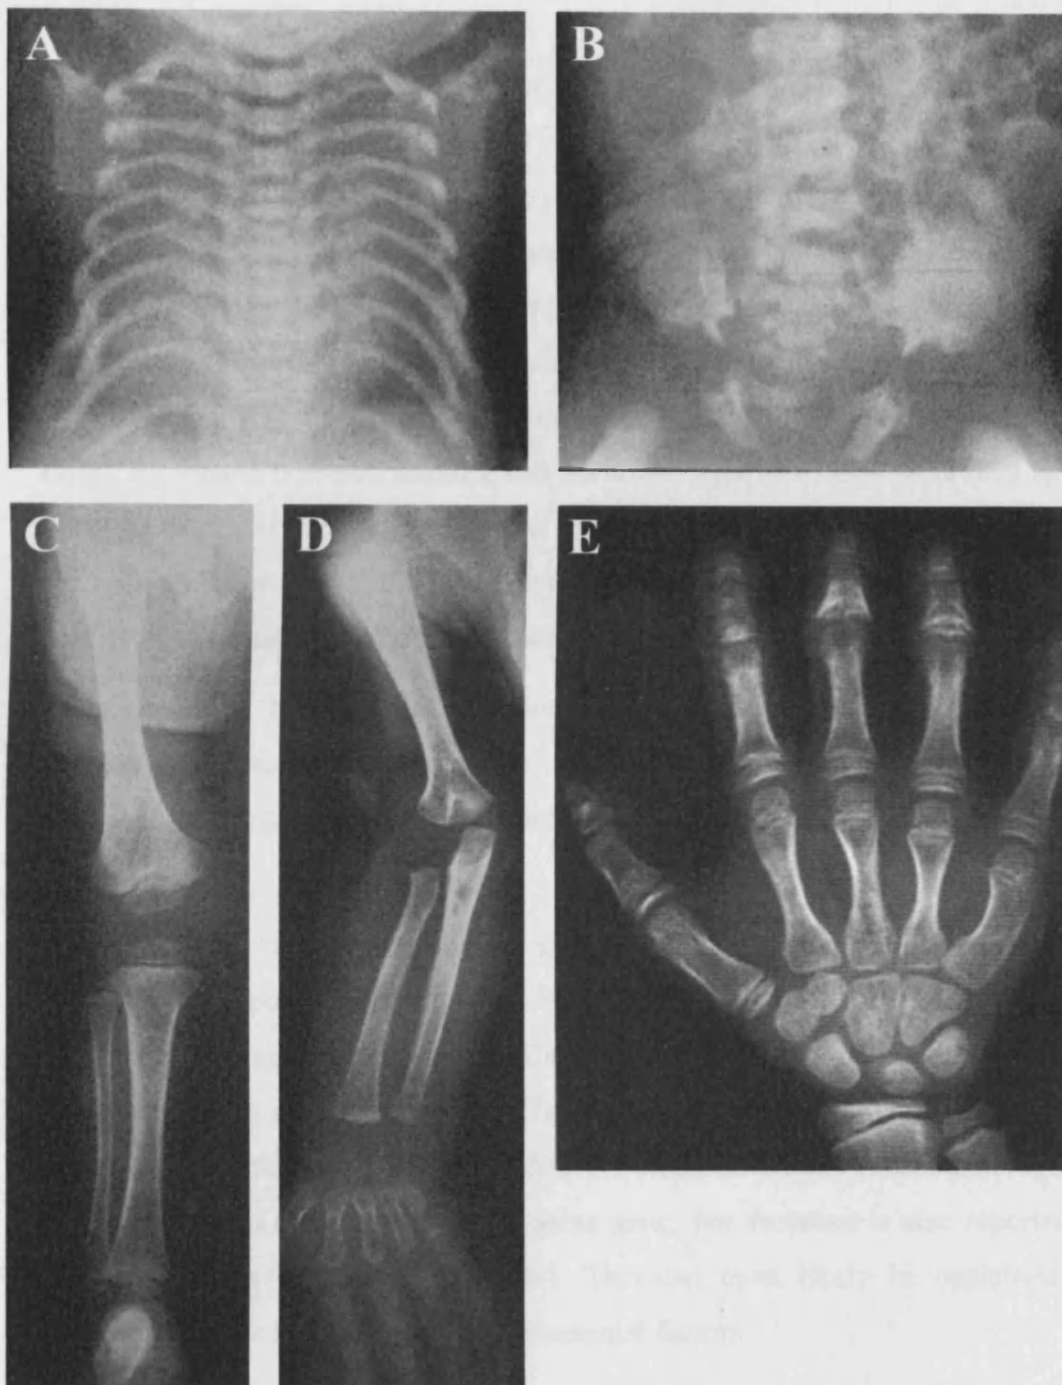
Radiographs showing the typical features of JATD. The thoracic cage is small and narrow with short ribs (A). The acetabular roofs have a 'trident' configuration (B). The proximal bones of the limbs are shorter than the middle bones (C and D). The middle and distal phalanges of the fingers are abnormally small (E).
